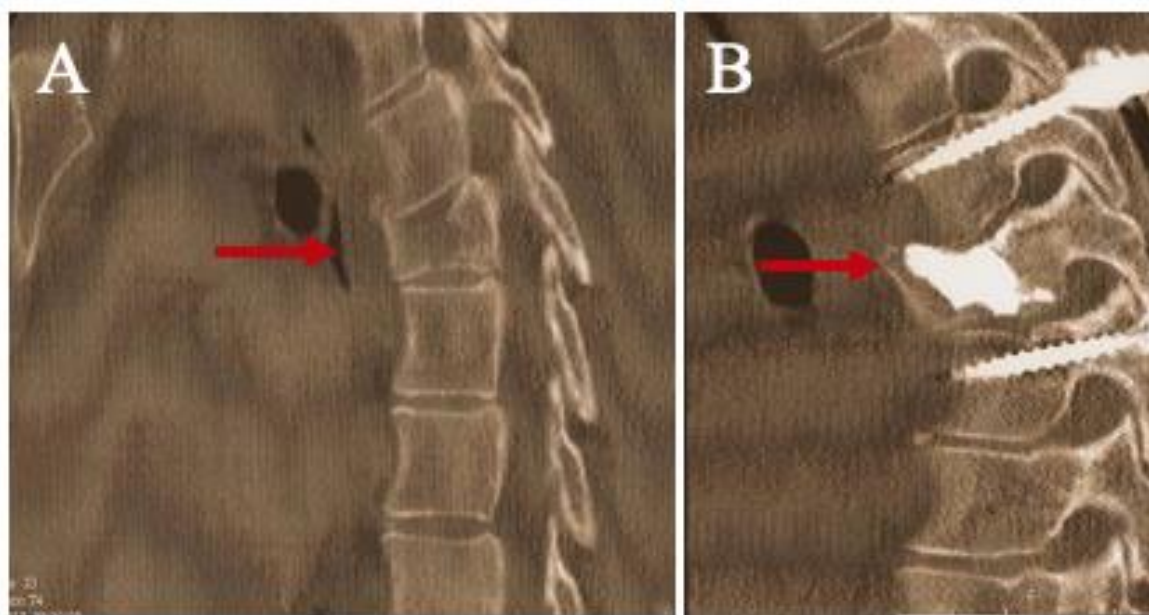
Case 4. (A) Sagittal reconstructed CT scan showing A.3.2 a thoracic vertebral fracture before (red arrow) (B) Postoperative sagittal reconstructed CT scan showing reduction of the thoracic fracture (red arrow).
